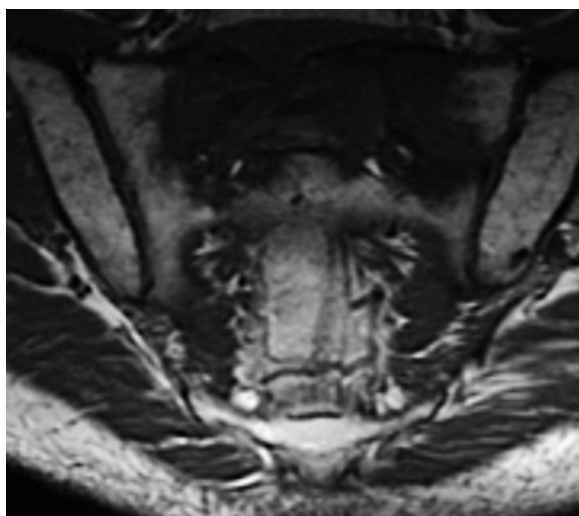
Axial T1-weighted MRI image of the sacrum demonstrates a large metastatic lesion to the patient's anterior sacrum.
